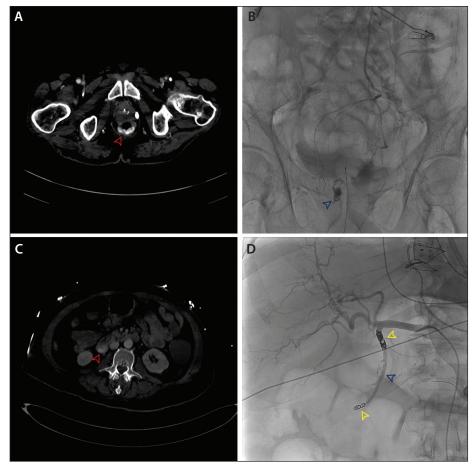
Demonstration of liquid embolic agents for GI bleeding. Axial CTA indicating active contrast extravasation in the rectum (red arrow) (A). Angiogram of the inferior mesenteric artery obtained after targeted embolization with NBCA (blue arrow) at the site of rectal hemorrhage (B). Axial CTA from a different patient showing active extravasation in the duodenum (red arrow) (C). Angiographic image acquired after dual embolization technique using coils (yellow arrows) and Obsidio liquid embolic (blue arrow) to achieve hemostasis in the duodenum (D).
